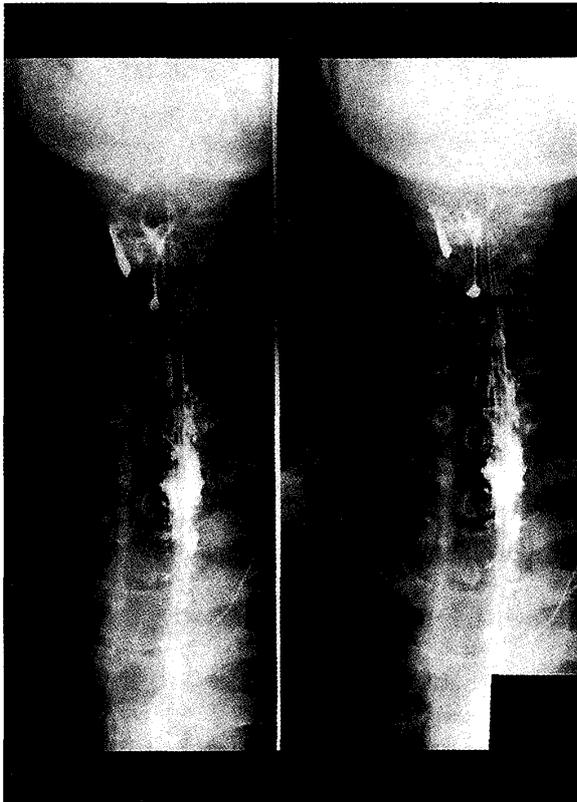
Barium X-ray examination of the esophagus (the 63rd day)
